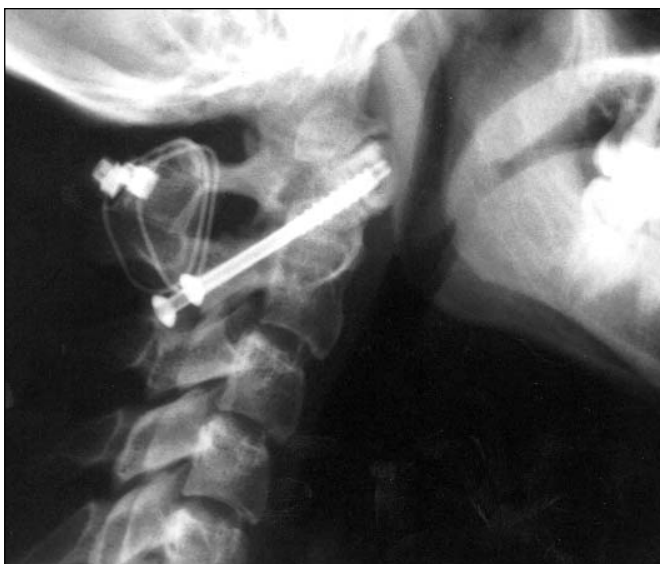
Immediate postoperative radiographic study demonstrating transarticular screw placement and the wired bone graft in position between C1 and C2.
